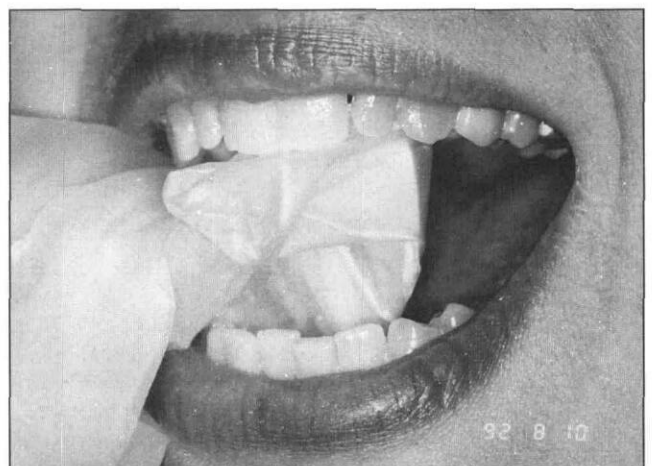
An example of latex-containing radiograph packet wrapped in a vinyl glove for latex-free dental management.
